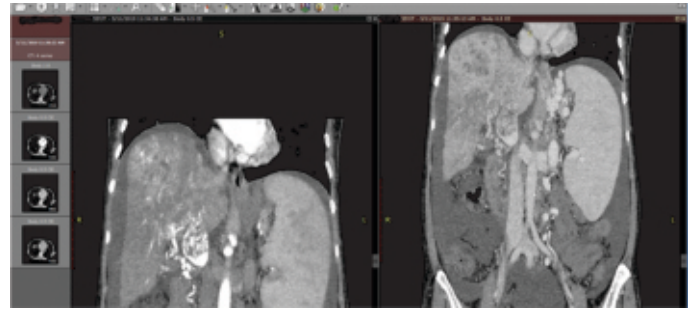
Coronal CT of a Patient from this Study Diagnosed as Malignant PVT shows Significantly Dilated Portal Vein, Enhancement of Thrombus on Arterial Phase (Yellow Arrow) and Washout on Portovenous Phase (Orange Arrow). Enlarged Liver with Multiple Arterial Enhancing Focal Defects, Splenomegaly and Ascites are also Noted
